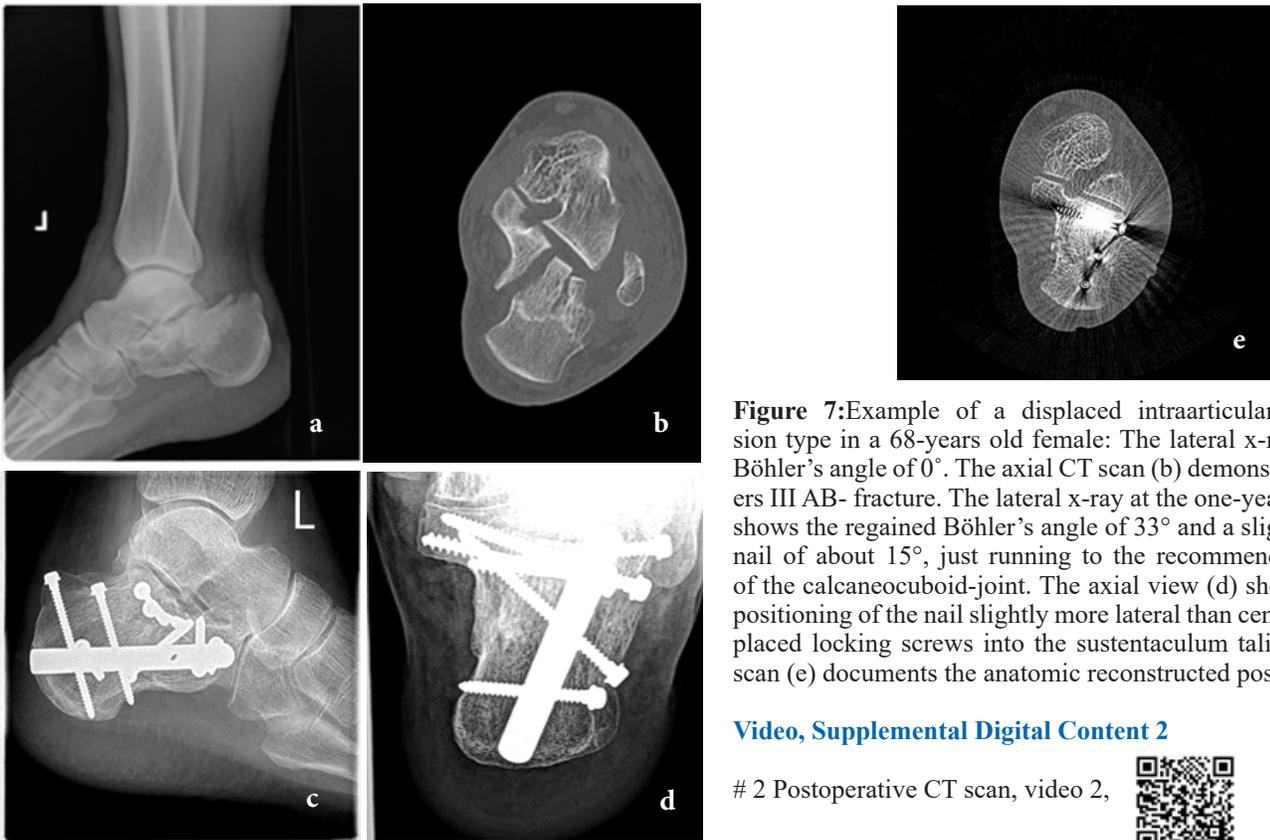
Example of a displaced intraarticular joint depression type in a 68-years old female: The lateral x-ray (a) shows a Böhler’s angle of 0°. The axial CT scan (b) demonstrates the Sanders III AB- fracture. The lateral x-ray at the one-year follow-up (c) shows the regained Böhler’s angle of 33° and a slightly ascending nail of about 15°, just running to the recommended half-height of the calcaneocuboid-joint. The axial view (d) shows the correct positioning of the nail slightly more lateral than central; the ideally placed locking screws into the sustentaculum tali. The axial CT scan (e) documents the anatomic reconstructed posterior facet.
